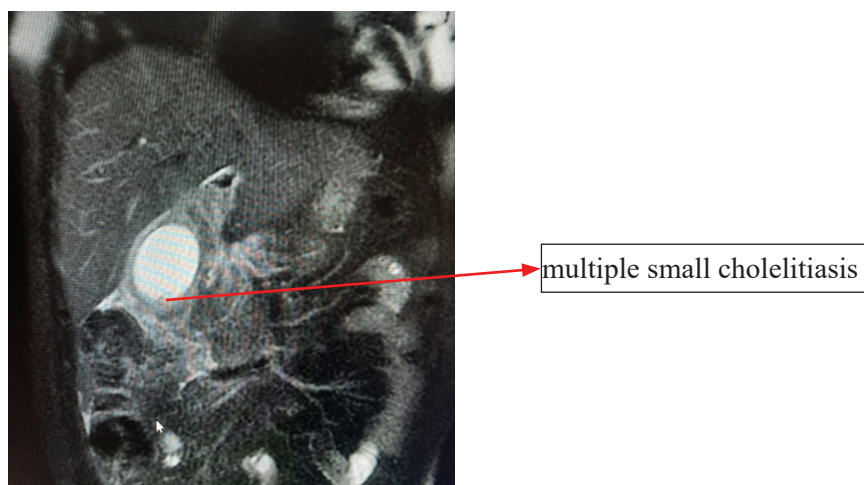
Abdominal MRI (2 months ago), showed multiple stones in gallbladder and normal pancreas
